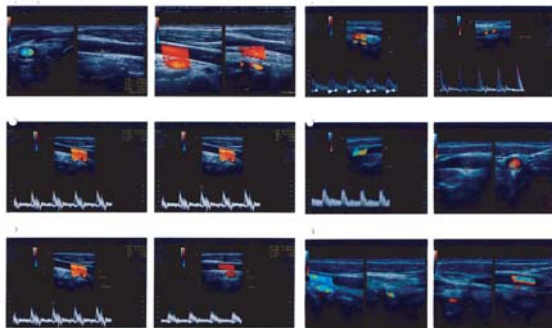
Doppler Ultrasound Scan of Carotid Artery
